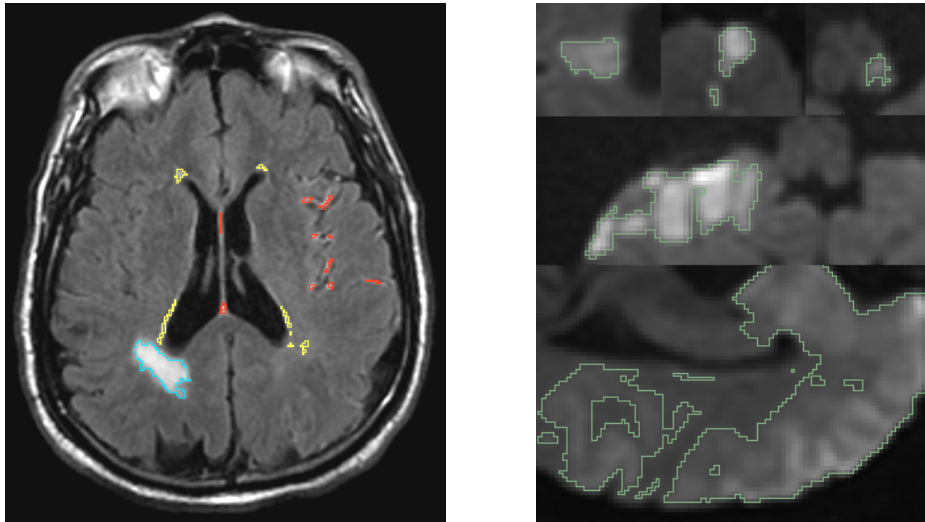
Left: T2-FLAIR axial slice. Stroke (blue outline) can appear anywhere in the brain, can vary dramatically in shape, and is hyperintense. Leukoaraiosis (yellow outline) is generally peri-ventricular, has a more predictable spatial distribution than stroke lesions, and is usually roughly symmetric across hemispheres. Imaging artifacts (red) that can interfere with automatic segmentation of pathologies. Right: Examples of stroke lesions manually outlined in green.
